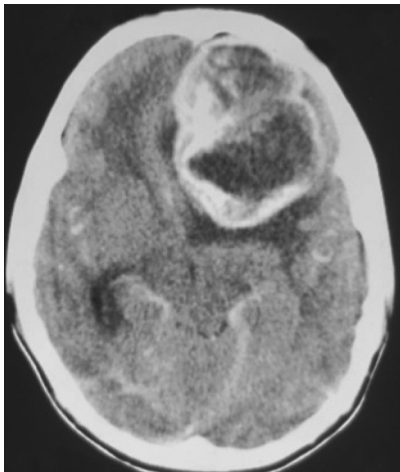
The contrast-enhanced CT scan showing a hyperdense, well-demarcated lesion with peripheral calcification in the left frontal lobe
